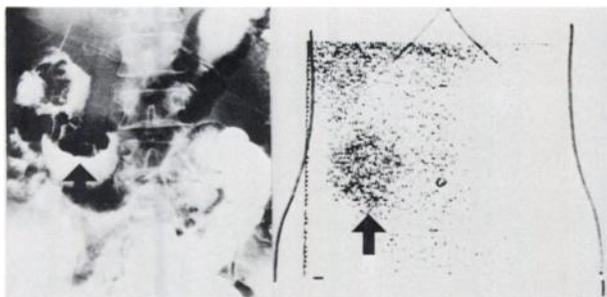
Case 11. Carcinoma of colon. X-ray of colon shows large filling defect in transverse colon due to carcinoma. Gallium-67 scintigram is strongly positive in region corresponding to filling defect of x-ray. This patient was operated 10 days after administration of ⁶⁷Ga-citrate. Radioactivity in cancer tissue was 2.2 times higher than that in surrounding unaffected colon tissue.
